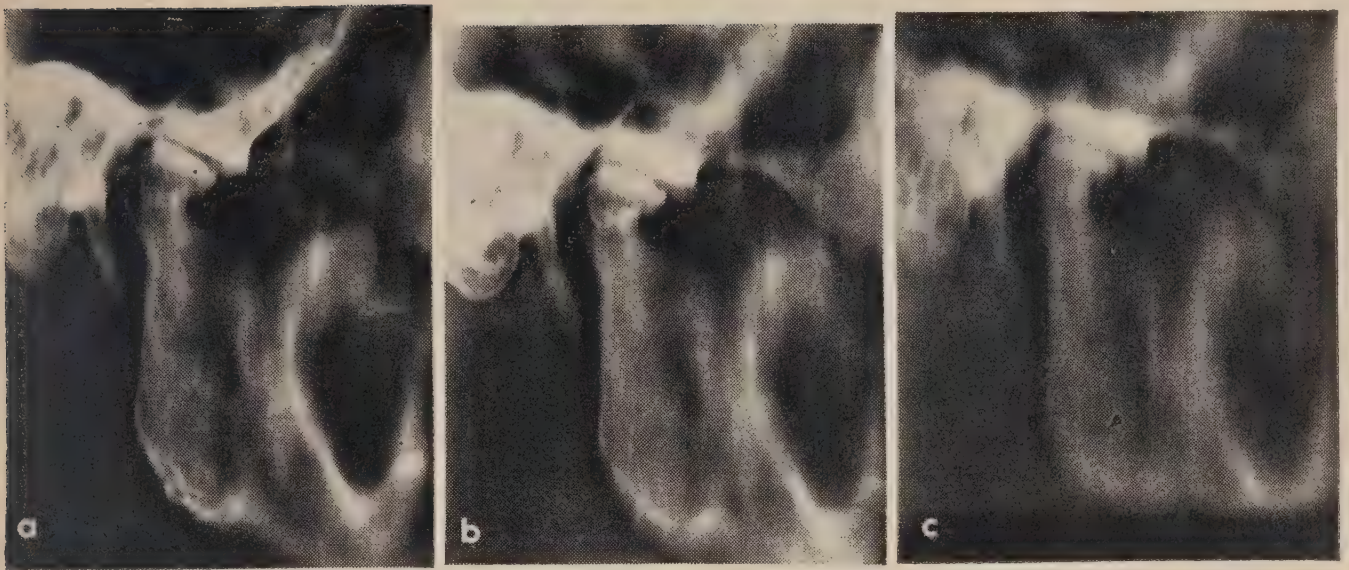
Three radiographic layers of a temporomandibular joint in which there are arthritic changes.
